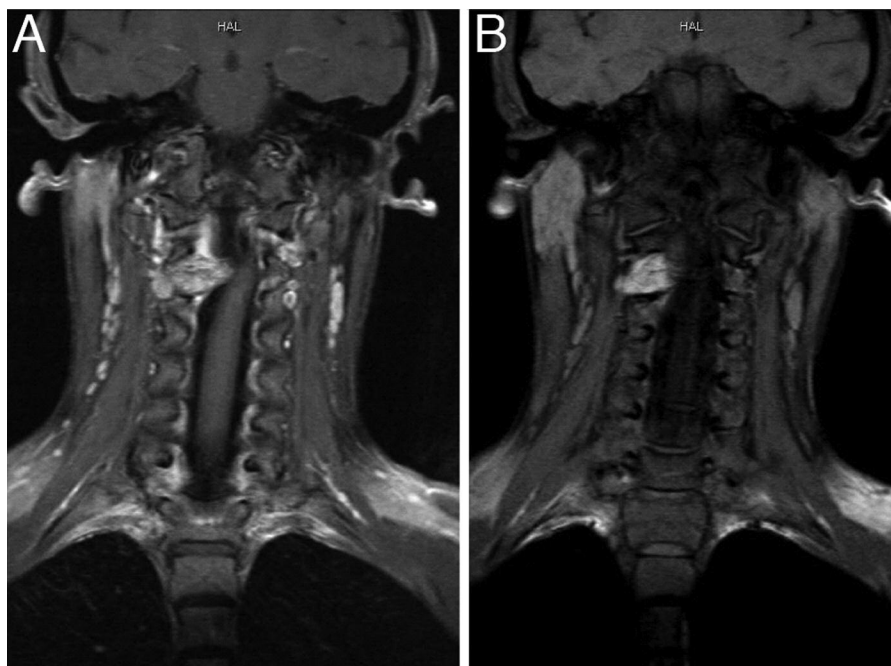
Coronal T₁-weighted MR images with (A) and without (B) gadolinium enhancement showing the dumbbell-shaped C2–3 enhancing lesion.
